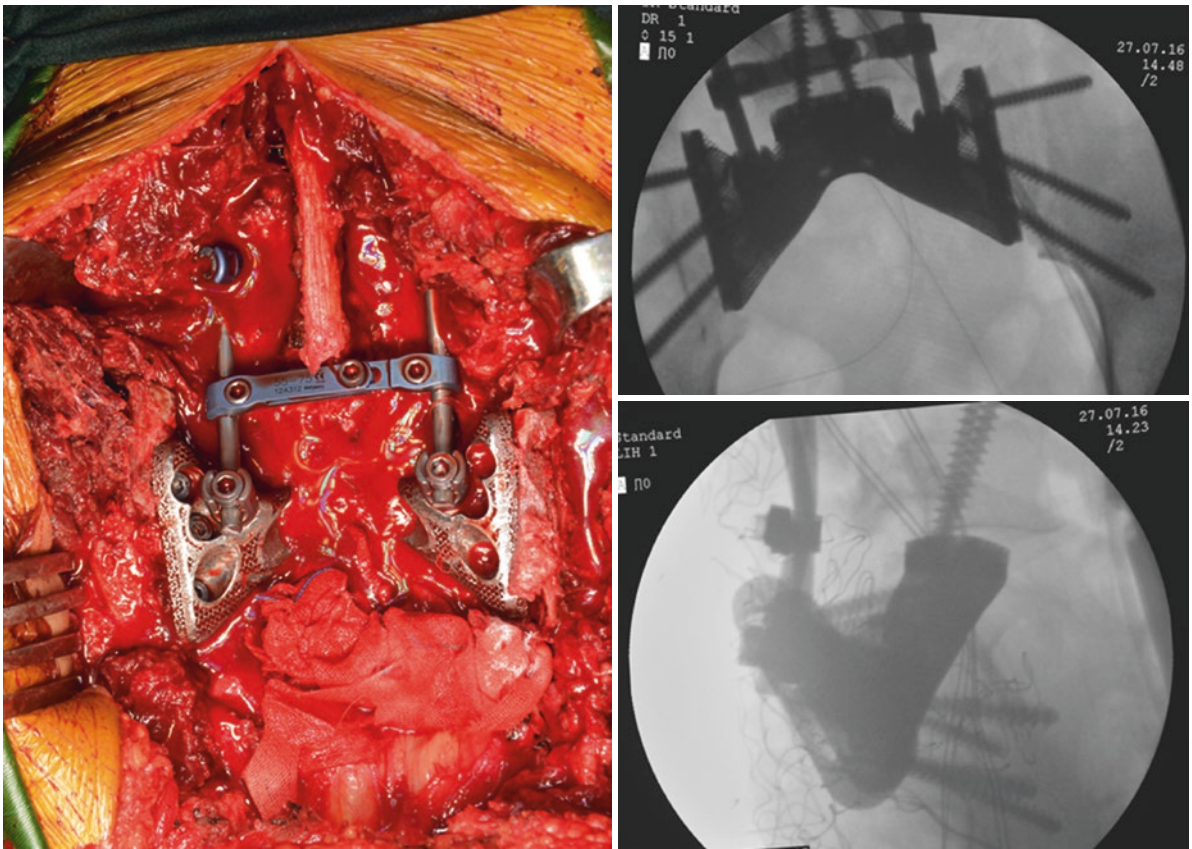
Intraoperative photograph and X-rays showing the endoprosthesis fixed in the bone defect between lumbar and pelvis by screws and rods
